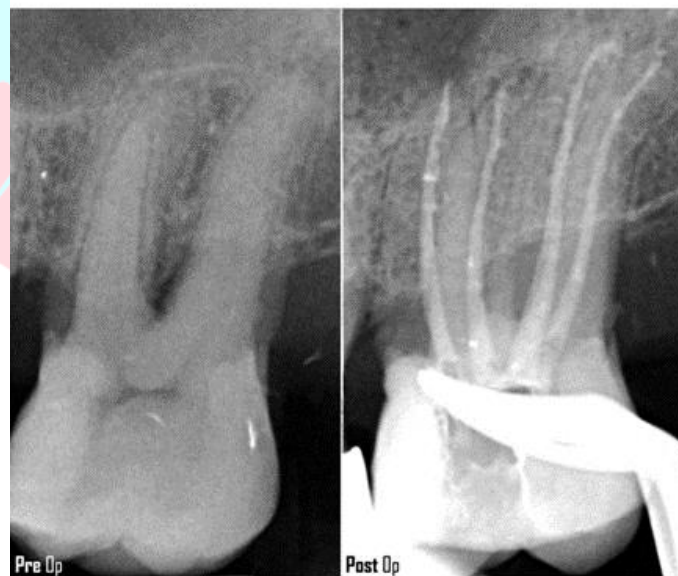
Pre and postoperative X-ray assessment
